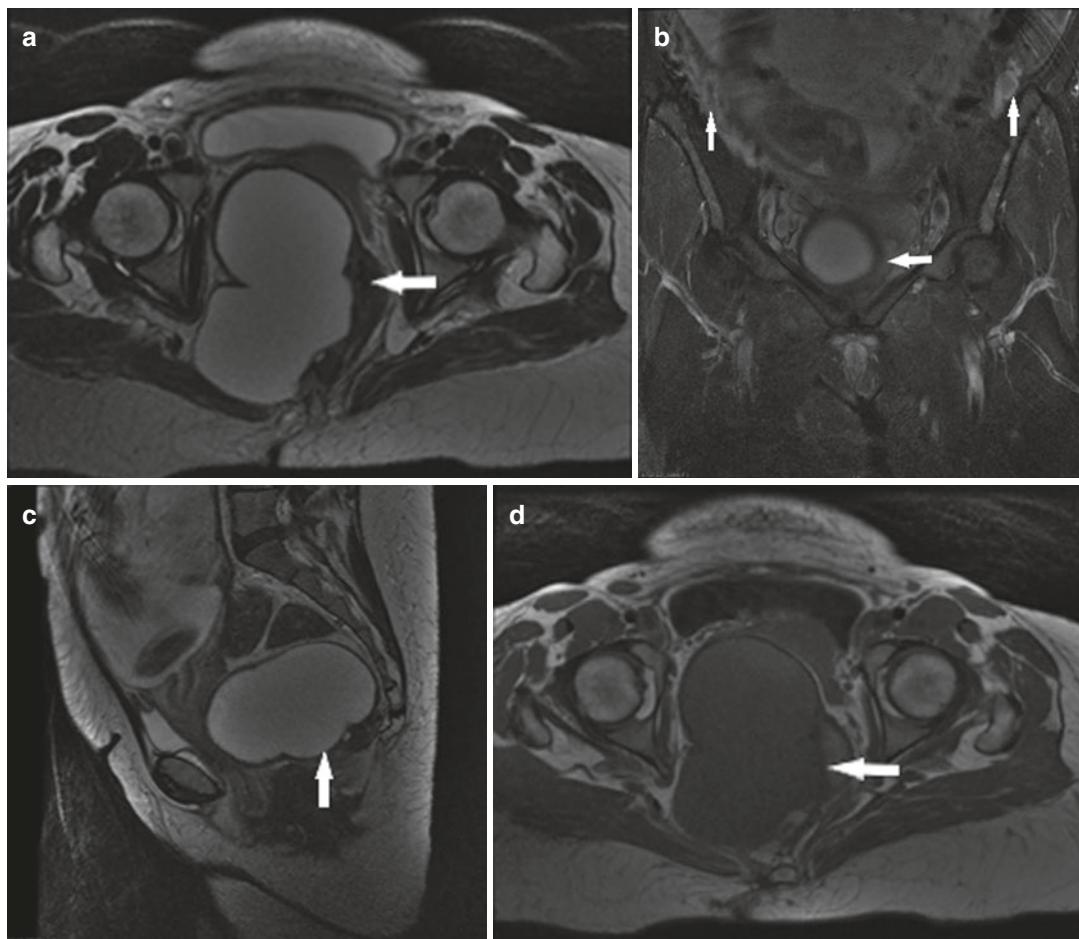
A 30-year-old woman at 28 weeks' gestation with acute pelvic pain. US showed a cyst adjacent to the posterior wall of the uterus. Axial (a), sagittal (b), and coronal (c) HASTE MR images, and axial T1-weighted
